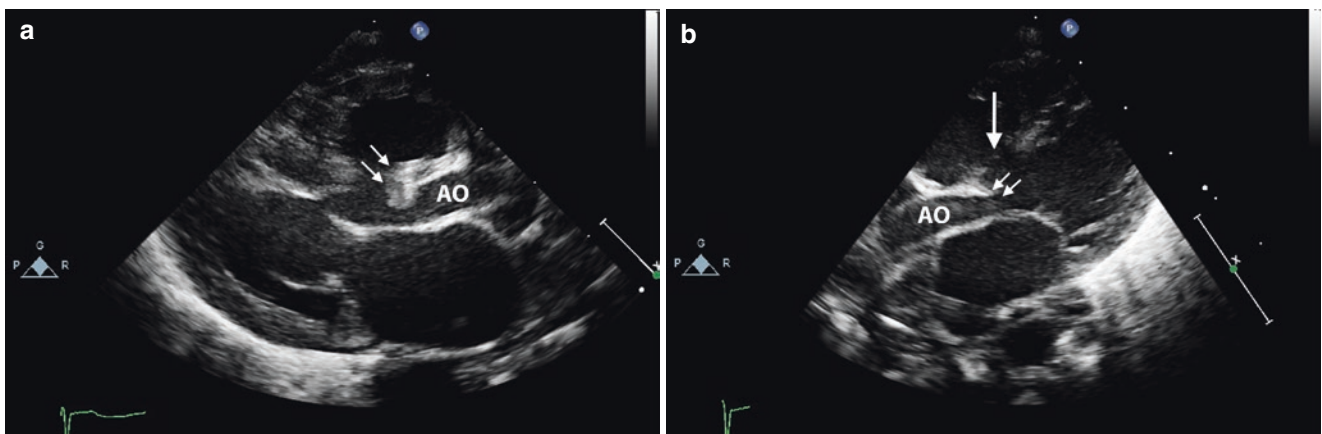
The parasternal long axis (a) in this patient with malalignment VSD shows posterior deviation of the outlet septum (*arrows*) obstructing the left ventricular outflow tract underneath the aortic valve
